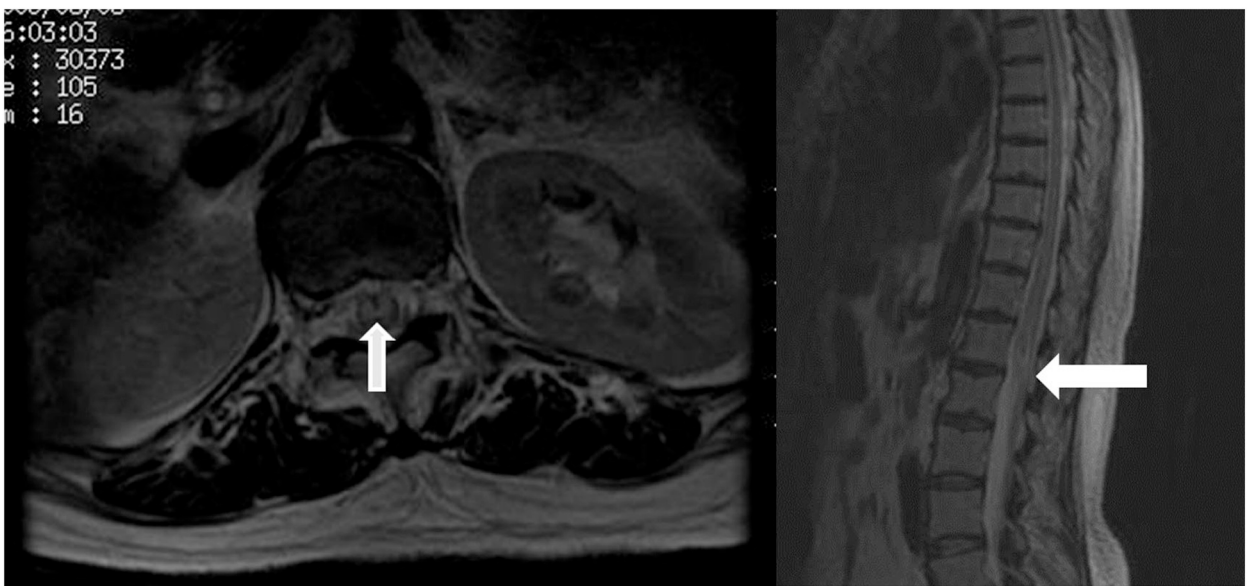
MRI images taken at the time of admission with a 1.5 T clinical scanner (SIGNA LX; GE Healthcare, Waukesha, WI, USA). (Left) Axial plane T2-weighted fast spin echo imaging. (Right) Sagittal plane T2-weighted fast spin echo imaging. MRI images showed intensified signal in the intraspinal, longitudinal regions from Th 8 to the conus medullaris (white arrows).
